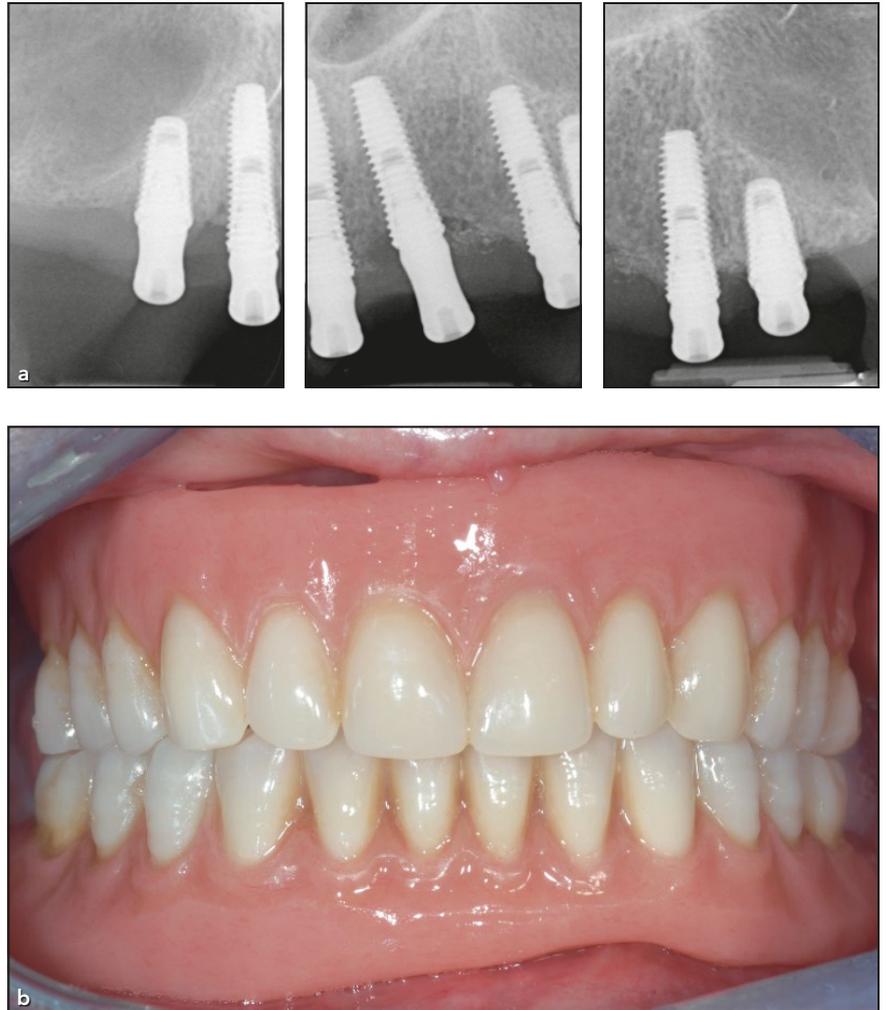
(a) At 1 year postrestoration, radiographs demonstrated good bone level on nonstudy implants. (b) The patient received new maxillary and mandibular restorations that improved her oral function.
